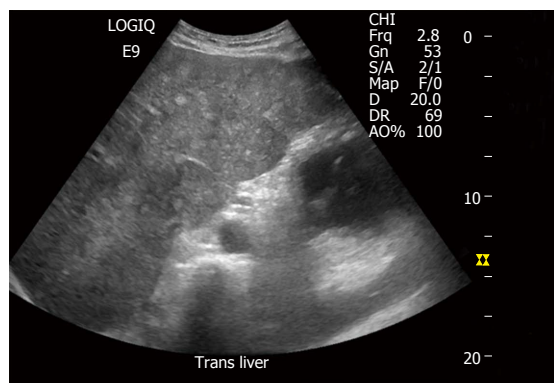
Ultrasound image with multiple small round hyperechoic nodules.
